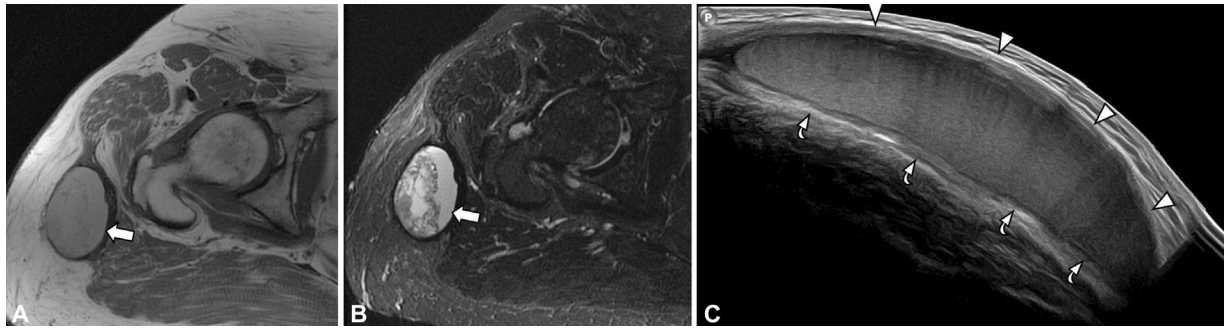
A 42-year-old woman with a firm mass (arrows) over the greater trochanter. The mass is hyperintense on the (A) axial T1-weighted magnetic resonance (MR) image and heterogeneously hyperintense on the (B) axial short-tau inversion recovery (STIR) MR image relative to skeletal muscle, compatible with hemorrhage. (C) Panoramic ultrasound (US) image shows a complex collection separating the subcutaneous (arrowheads) and superficial fascial (curved arrows) layers consistent with a Morel-Lavallée lesion.
